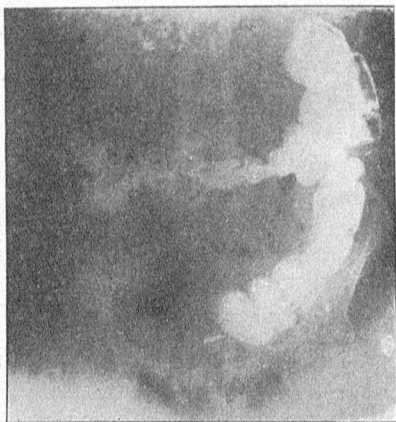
No. 6040. X-ray after right colectomy, 11 hours after barium meal, showing ileum empty.
